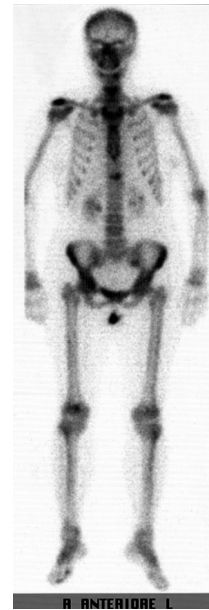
B.A., male, 28 years of age, tubercular spondylodiscitis at L3- L4. Tc-99m total-body bone scintigraphy.
